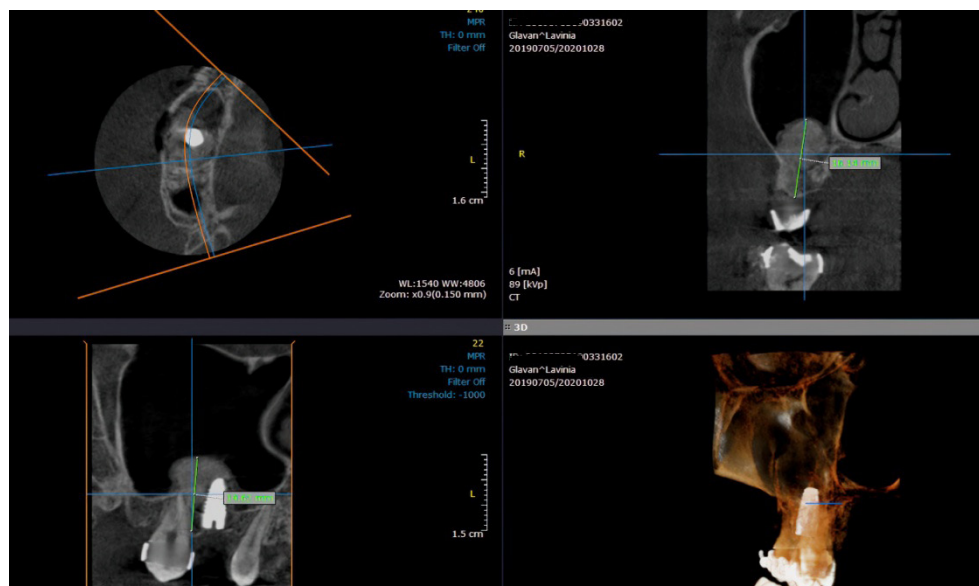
Postoperative CBCT measurement of the distal bone height of the edentulous site using xenograft materials.
